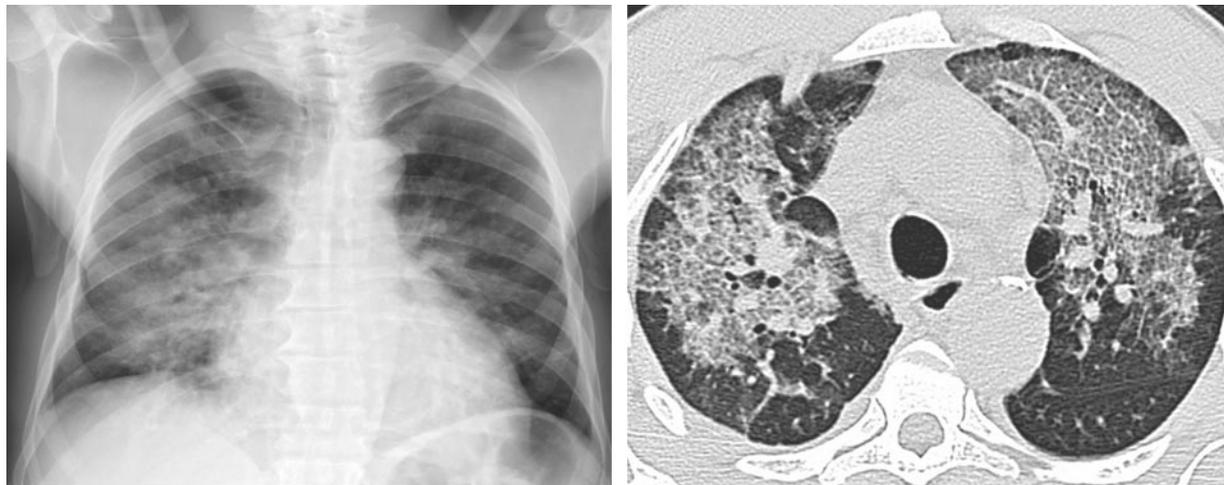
Acute chest syndrome in a 49-year-old man who presented with progressive shortness of breath and fever after an intravenous cocaine binge. (a) Chest radiograph shows abnormal bilateral parenchymal opacities, which are more confluent in the right midlung zone. (b) High-resolution computed tomographic (CT) scan demonstrates diffuse bilateral reticular opacities with superimposed thickening of inter- and intralobular interstitium (“crazy paving pattern”).
